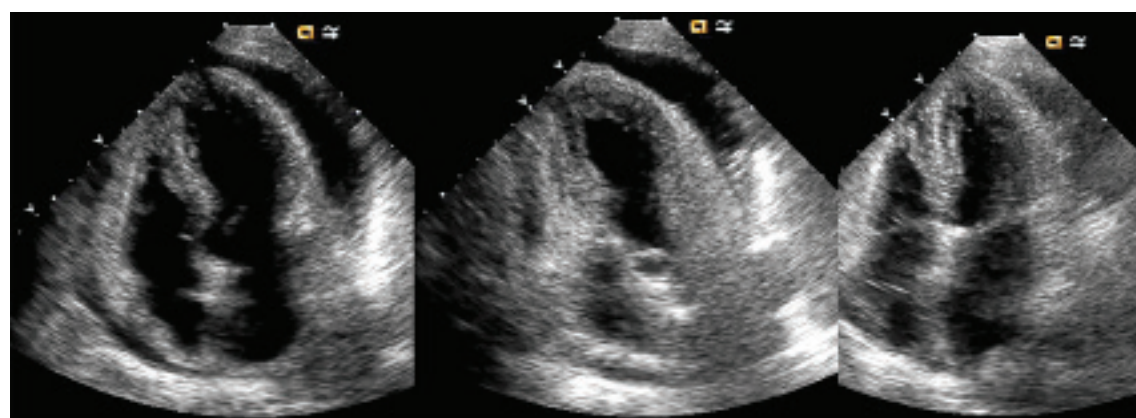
Echocardiographic frames showing pre-pericardiocentesis effusion (left), pericardiocentesis with introduction of echo bubble contrast (middle panel), and post pericardiocentesis after the effusion is removed (right).
